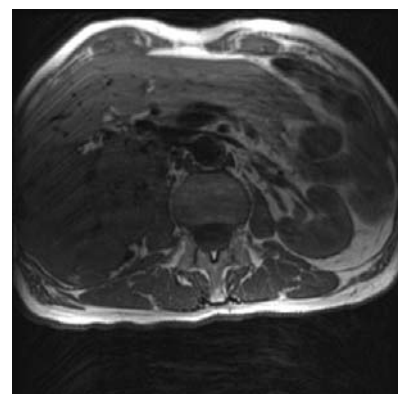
MR image of left renal vein with distended medial portion that contains clearly seen thrombotic material
